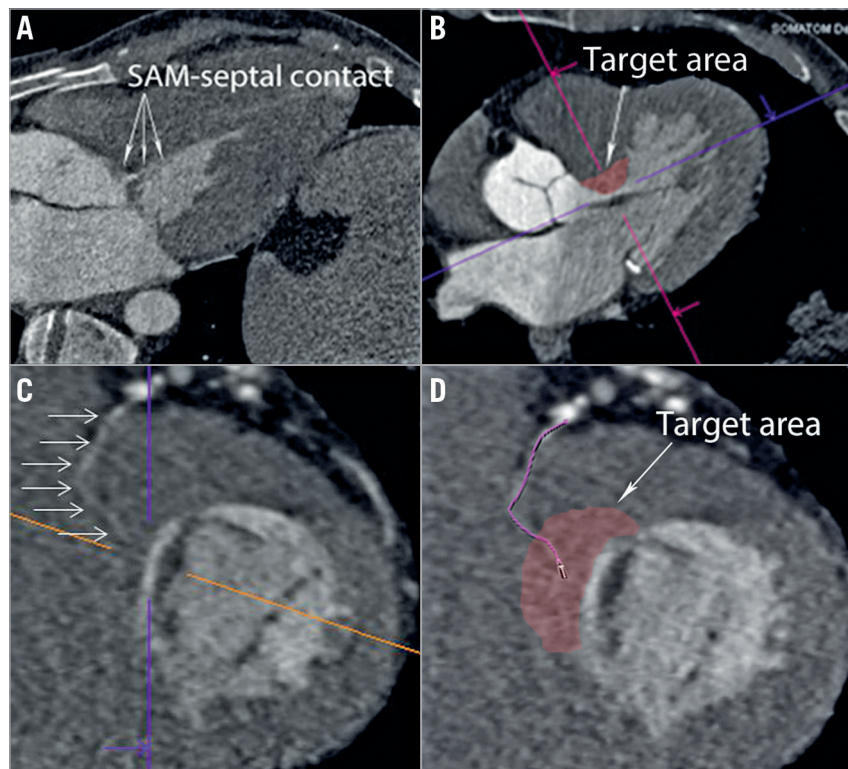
Septal artery tracking in 2D CT. A) Three-chamber systolic CT image displaying SAM of the MV. The contact area is seen in the basal septum. B) The target area of myocardium in the basal septum is located at the centre of the coloured lines – a short-axis view is displayed in Panel C. The centre point of these lines is the same target myocardium in each image. This myocardium is then surveyed for evidence of a coronary artery; the vessel is traced back to its parent epicardial vessel and examined (D).
